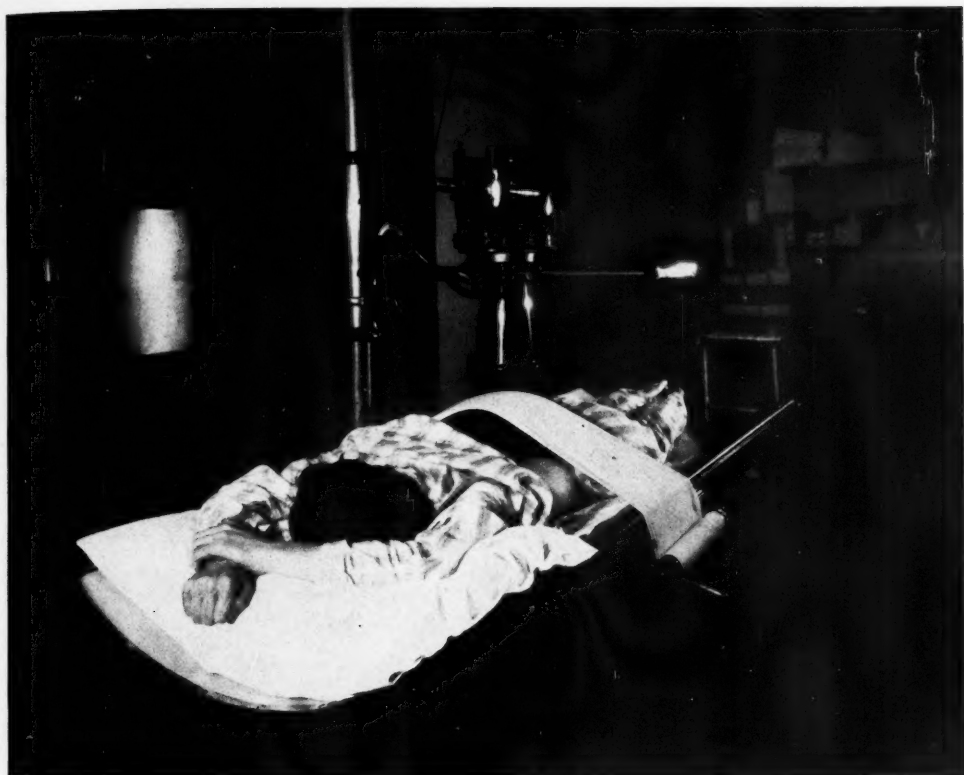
Position of the patient on the roentgenographic table in making cholecystograms. The patient is comfortable, relaxed, his head is turned to the right side and his toes are over the end of the table. No discomfort from pressure points.
